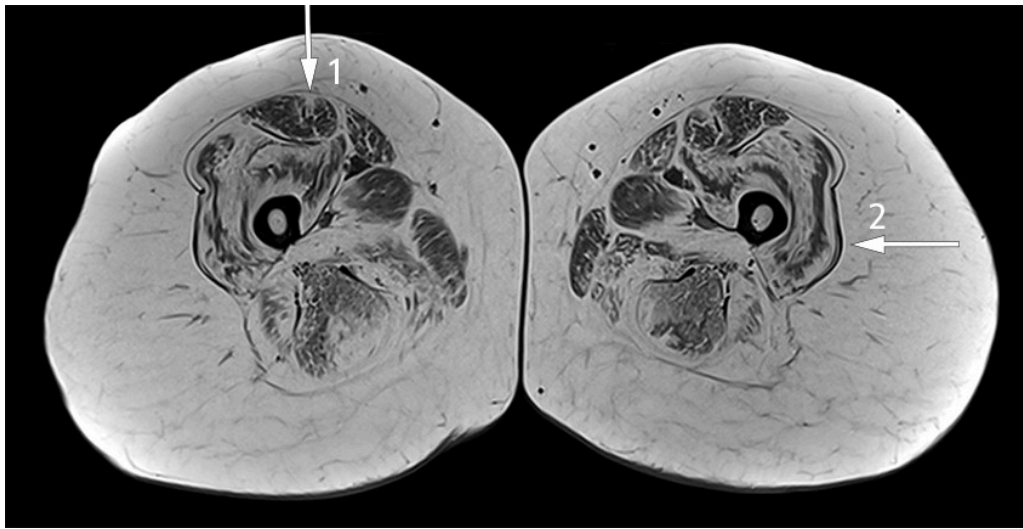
Transversal T1-weighted MRI image of the thighs reveals symmetrical pathological fatty infiltration in the muscles with a 'target sign' in the rectus femoris muscle (arrow 1) which represents central fatty infiltration with better preserved musculature at the periphery, and a 'sandwich sign' in the vastus lateralis muscle which represents peripheral fatty infiltration with better preserved musculature in the central region (arrow 2) (12–14).
